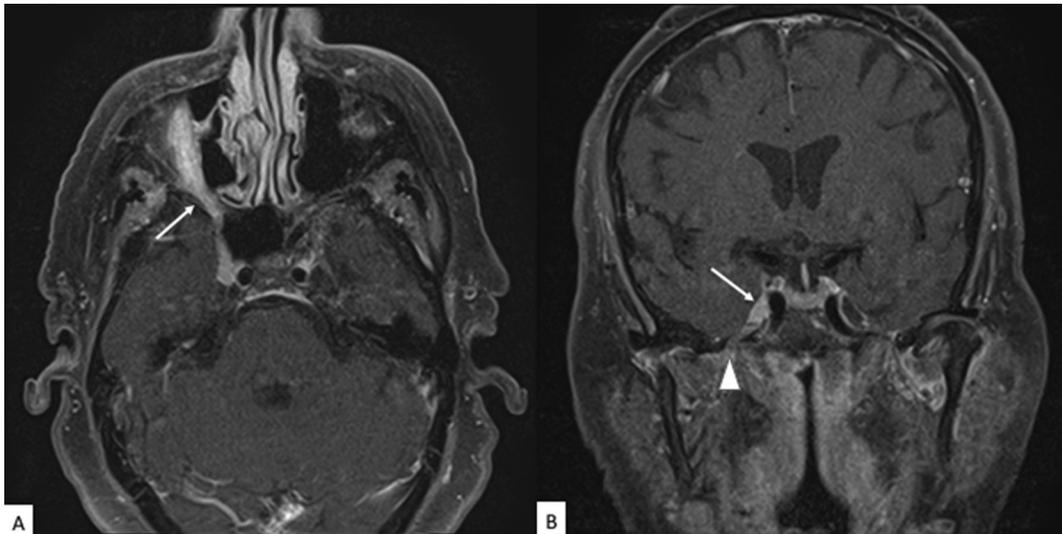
Axial (A) and coronal (B) T1-weighted preoperative MRI images with contrast demonstrating an enhancing lesion along the course of the maxillary and infraorbital nerves (arrows). Careful examination of the coronal image demonstrates additional enhancement through foramen ovale (arrowhead).
